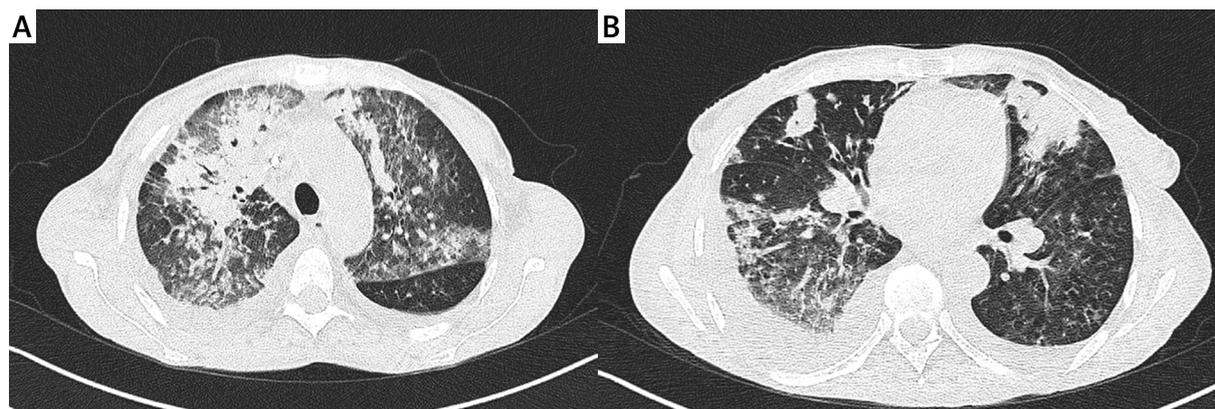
High-resolution computed tomography scans of pulmonary lesions at the time of diagnosis in February 2020.
